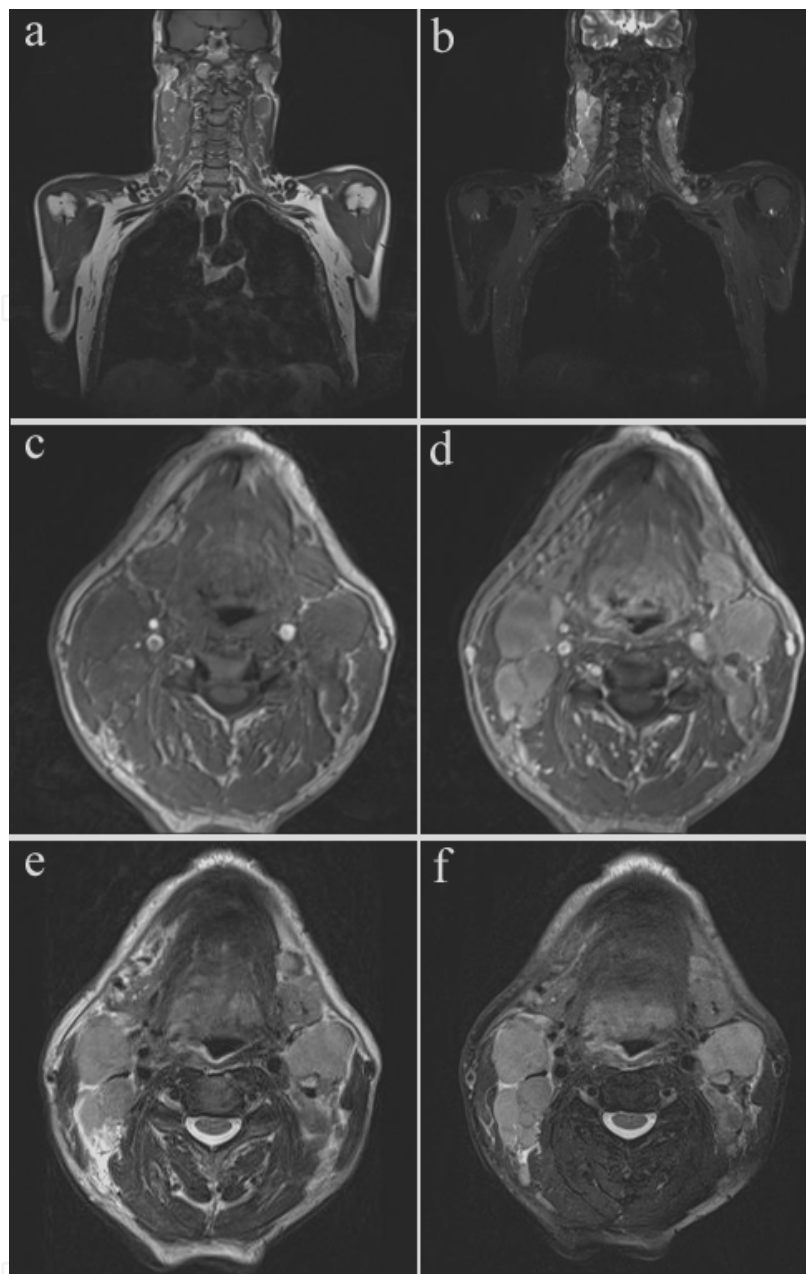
MR images in a 57 year-old male patient with diffuse large B-cell lymphoma. Multiple lymph node lesions in the cervical region are shown: A coronal slice of T2-weighted image without fat-suppression (a) and the corresponding coronal slice of T2-weighted image with fat suppression (b). An axial slice of T1-weighted image before contrast agent injection and the corresponding axial slice of T1-weighted image with contrast enhancement (d). An axial slice of T2-weighted image without fat suppression (e) and the corresponding axial slice of T2-weighted image with fat suppression (f).
